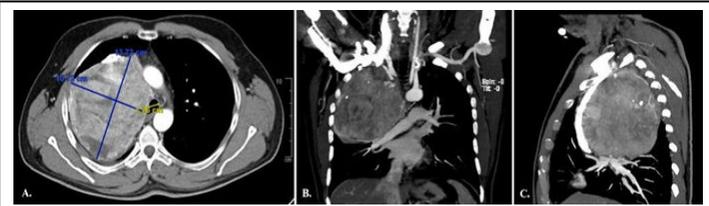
Preoperative CT with intravenous contrast. A 13.7 × 10.7 × 11.5 cm heterogeneous mass.
